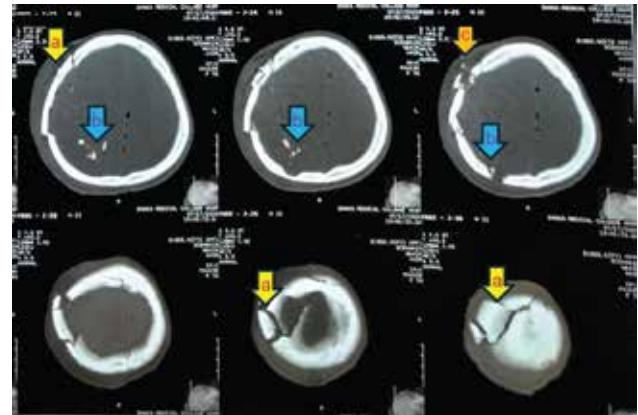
CT scan of Head - Bone window
